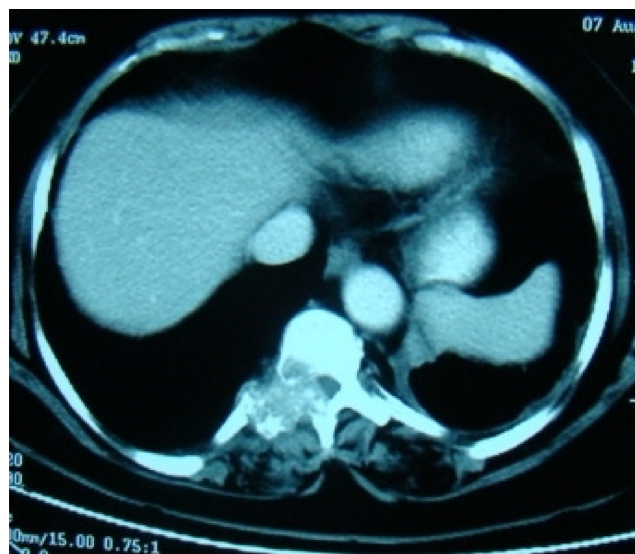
Contrast-enhanced computed tomography of chest and abdomen shows destruction of dorsal vertebrae.
